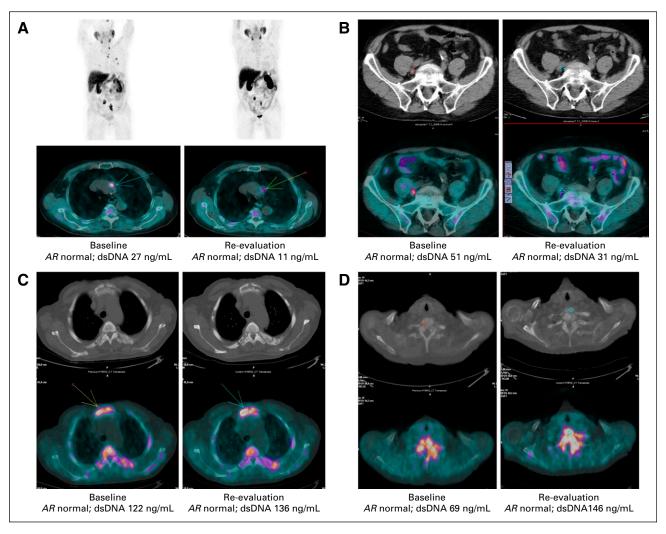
Impact of baseline androgen receptor (*AR*) copy number, cell-free DNA, and choline uptake by ¹⁸F-fluorocholine positron emission tomography/computed tomography on clinical outcome in patients with castration-resistant prostate cancer who were treated with abiraterone or enzalutamide. dsDNA, double-stranded DNA. (A) Patient 1; 78 years of age; Gleason score 9 (4+5); 10 sites of nodal localization; baseline *AR* normal; TLA = 290576.3, MTV = 50.26; SUV_{max} = 68.52: treatment with abiraterone postdocetaxel for 7 months. Re-evaluation after 45 days of therapy: early good FCH-PET/CT response in mediastinal and abdominal nodal metastases. (B) Patient 2; 80 years of age; Gleason score 7 (3+4); four sites of nodal localization; baseline *AR* gain; TLA = 23745.7; MTV = 14.67; SUV_{max} = 12.97; treatment with abiraterone postdocetaxel for 30 months. Re-evaluation after 80 days of therapy: partial FCH-PET/CT response. (C) Patient 3; 85 years of age; Gleason score 8 (4+4); 26 sites of bone localization; baseline *AR* normal; TLA = 1292423.8; MTV = 279.85; SUV_{max} = 206.49; treatment with abiraterone postdocetaxel for 12 months. Re-evaluation after 90 days of therapy: stable disease. (D) Patient 4; 87 years of age; Gleason score 8 (4+4); 10 sites of bone localization; baseline *AR* gain; TLA = 599060; MTV = 142; SUV_{max} = 49.25; treatment with enzalutamide postdocetaxel for 5 months. Re-evaluation after 40 days of therapy: progressive disease.
